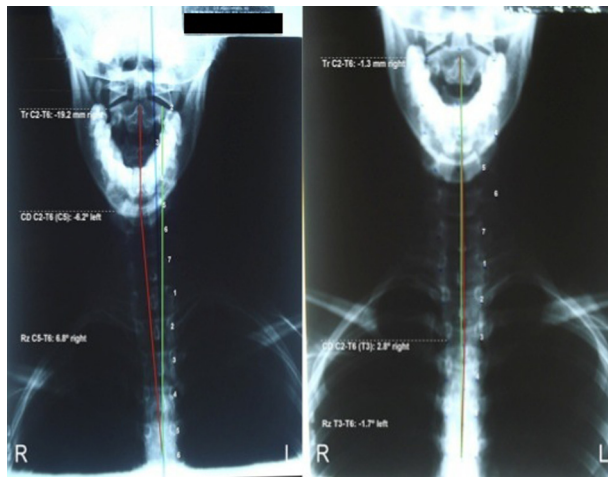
Left: Initial AP radiograph showing a 19.2 mm right head translation with a corresponding 6.2° CD angle to the left, and a 6.8° Rz angle to the right; Right: A 1.3 mm right head translation with a 2.8° CD angle to the right and a 1.7° Rz angle to the left.
